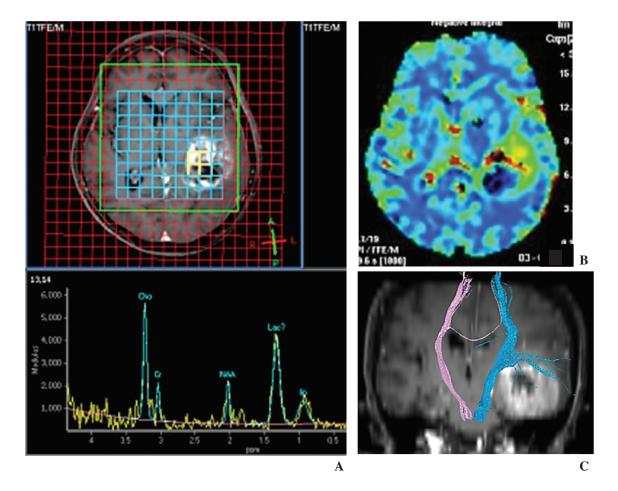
Hight grade glioma (A) MRS, (B) p MRI (CBV), (C) DTI.MRS shows definitely increased Cho, Lac and Lip peaks in brain tumor. The NAA is markedly decreased. pMRI demonstrates increased blood volume at the periphery (arrow in B) and no blood supply of the central necrosis. DTI shows the relationship between the tumor and the ipsilateral corticospinal tract.
